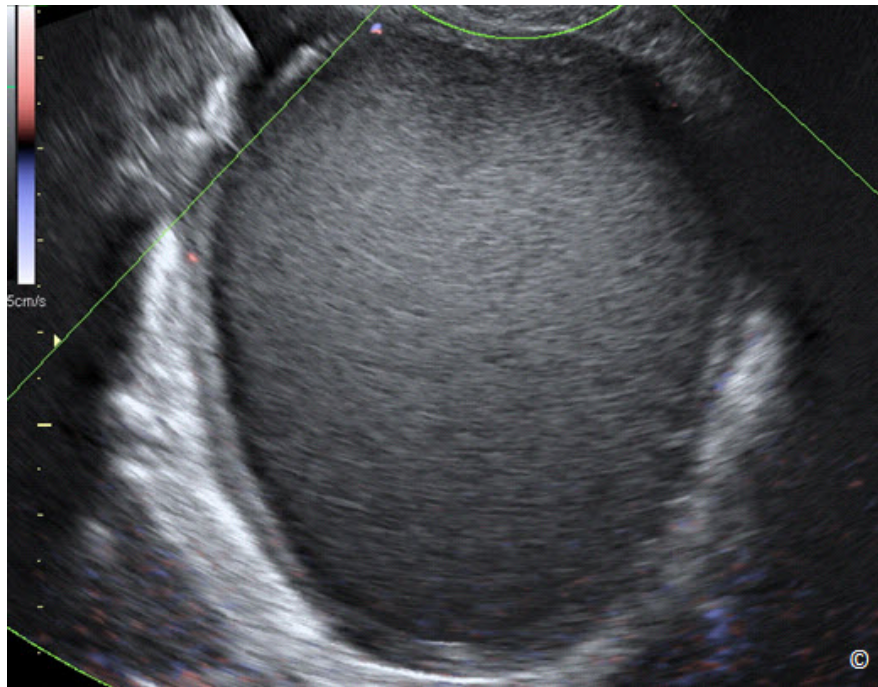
Transvaginal ultrasound with color Doppler of an endometrioma showing a unilocular mass with ground glass appearance. Note the absence of vascularity within the content of the mass on low velocity scale (5 cm/sec) color Doppler.
